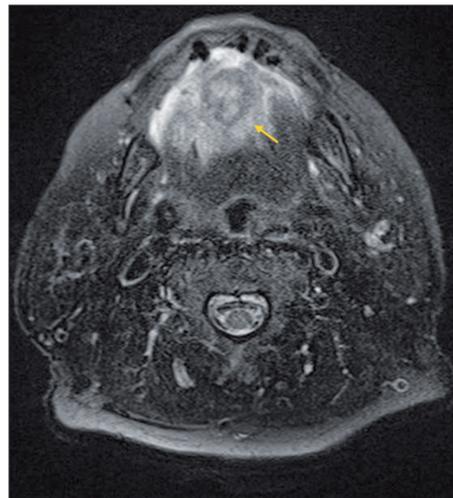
Facial MRI examination of the case 2, axial section.
